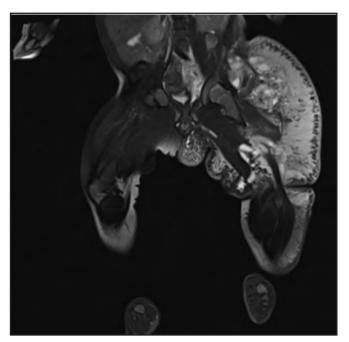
MRI of pelvis and lower limbs of Baby A.
